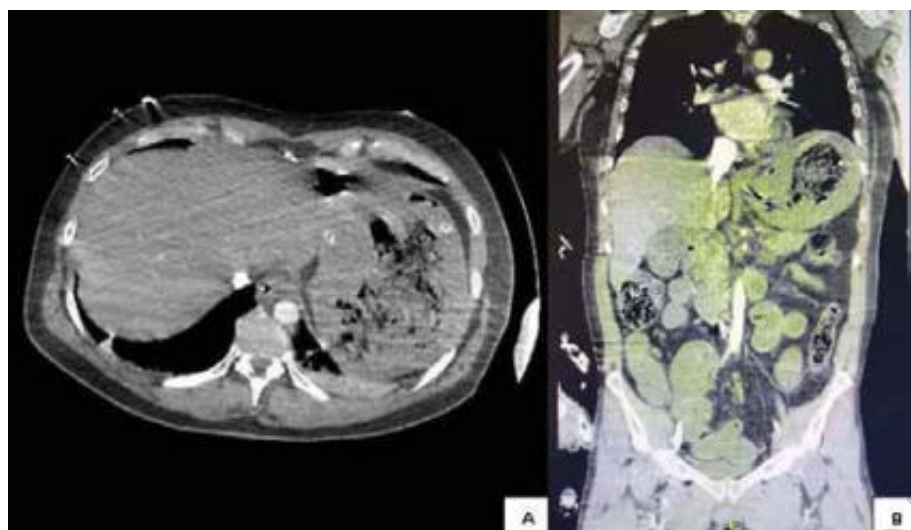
Rectos figure 1. CT showing gastric dilation with haematic content without contrast medium extravasation (A-B).
